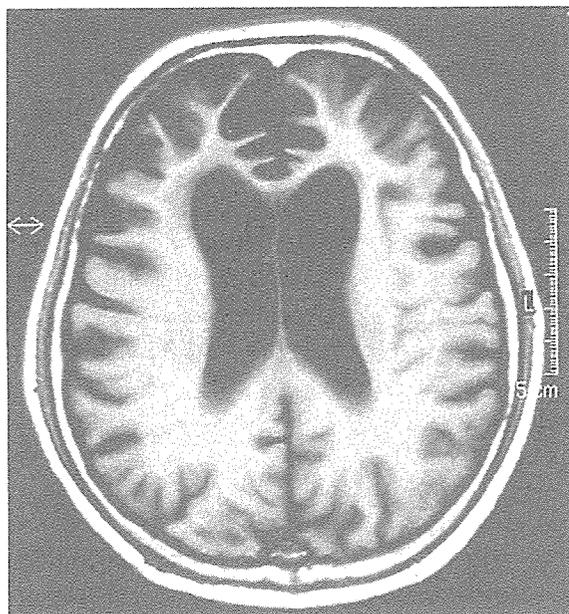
FTD (Pick型) 患者の頭部 MRI T1 強調像
